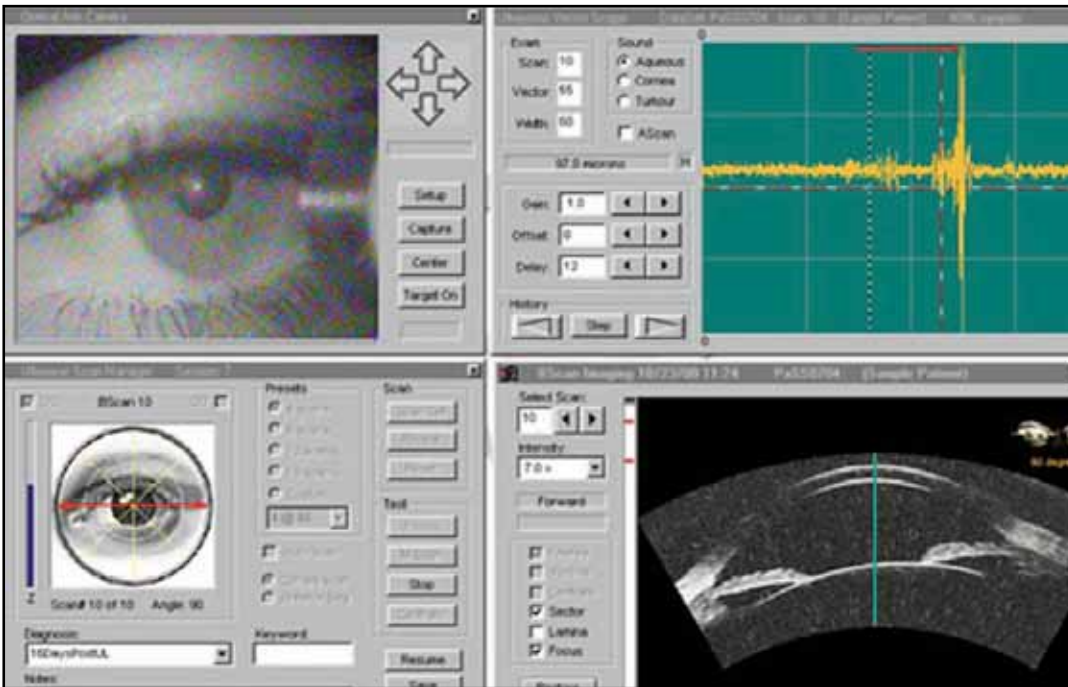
Artemis advanced control display panel. The upper left quadrant shows an infrared real-time video image of the eye being scanned in which eye position can be verified and monitored during scanning. The lower left panel is used for scan motion control, while the upper right panel displays the raw ultrasound echo data. In this screen-shot, the lower right anterior segment scan was known to have been taken in the horizontal plane when the eye was fixating on a light source co-axial with an alignment beam that is centered on the corneal vertex (corneal reflex visible). The patient’s angle kappa produces a geometrical tilt of the anterior segment compared to the visual axis (green line). The corneal reflex is an excellent landmark for correlating scans taken before and after anatomy by subtraction imaging.
